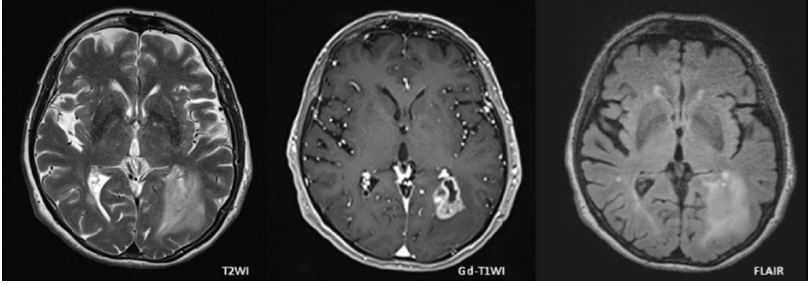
Comparison of conventional MRI sequences for imaging a left occipital GB. From left to right: T2-weighted MRI, gadolinium-enhanced T1-weighted MRI and fluid attenuated inversion-recovery (FLAIR) MRI. Adapted from [14].
